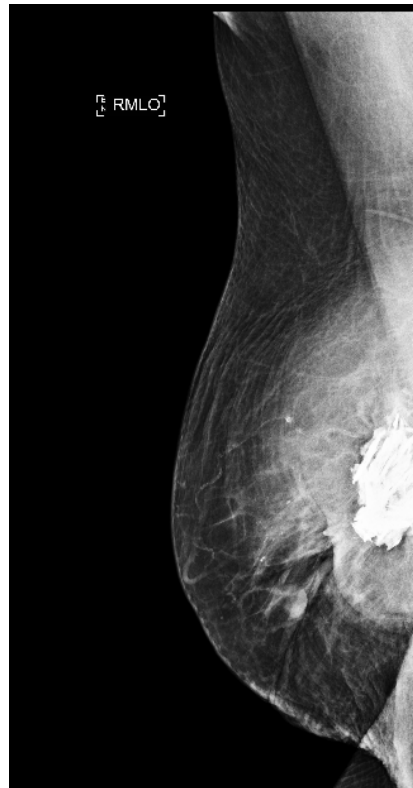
Single MLO mammographic projection of the right breast, performed 3 years following lumpectomy, and 9 months following self-explantation, shows coarse calcification in the central breast consistent with the retained portion of the calcified implant capsule. No findings were seen by mammography or sonography to suggest cancer recurrence.
